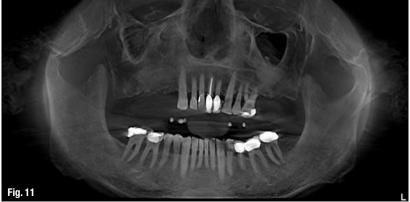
10_Clinical photograph of provisional restoration at three months after surgery. Fig. 11_Panoramic CBCT reconstruction of a 62-year-old male patient missing multiple teeth in the maxilla. Bilateral sinus-lift procedures had been performed six months prior.
